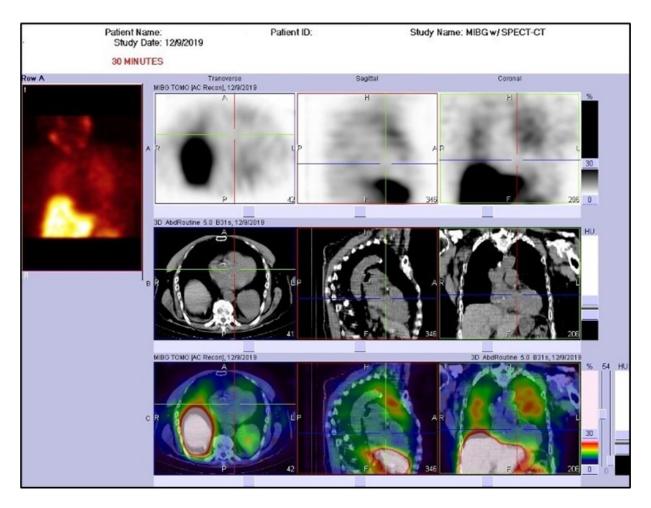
SPECT-CT image of the heart at 30 minutes (quality control)
